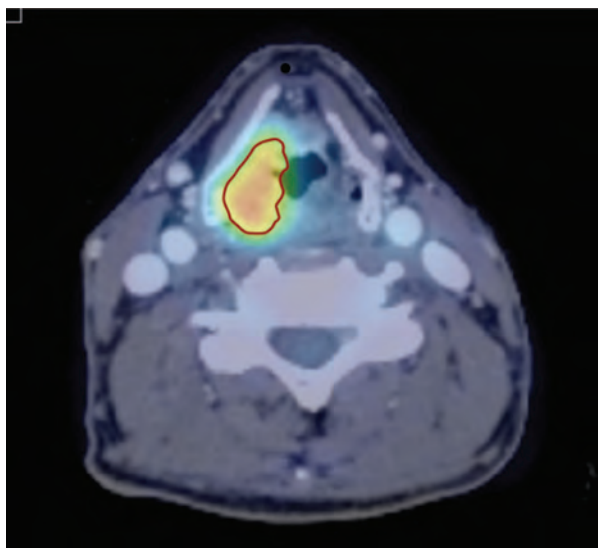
Fusion of the FDG-PET image on the planning CT (axial view). The GTV (red contour) has been automatically delineated using a gradient-based method.
